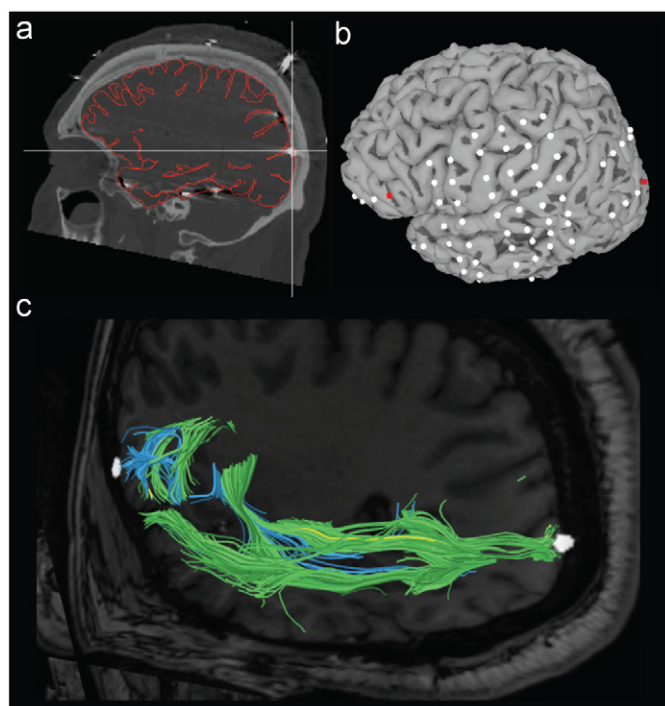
Electrode localization and functionally-constrained MR diffusion tractography pathways in a single patient. (a) CT scan of patient with intracranial electrodes visible as bright intensity regions. Outlines of the reconstructed cortex are indicated in red, each electrode presents itself as an artifact (occipital electrode highlighted by crosshairs). (b) Surface model of the brain generated from T1-weighted MRI with electrodes, whose coordinates were found on the CT scan and then modeled on the reconstructed cortical surface. Red electrodes (frontal and occipital) showed significantly higher gamma power during working memory delay compared to baseline and (c) White matter tracts (green, blue, and yellow) adjacent to frontal and occipital gamma electrodes (white spheres). Green pathways have terminations in brain tissue adjacent to the occipital electrode, blue pathways to the area around the frontal electrode, and yellow pathways terminate near both electrodes. (For interpretation of the references to color in this figure legend, the reader is referred to the web version of this article.)
